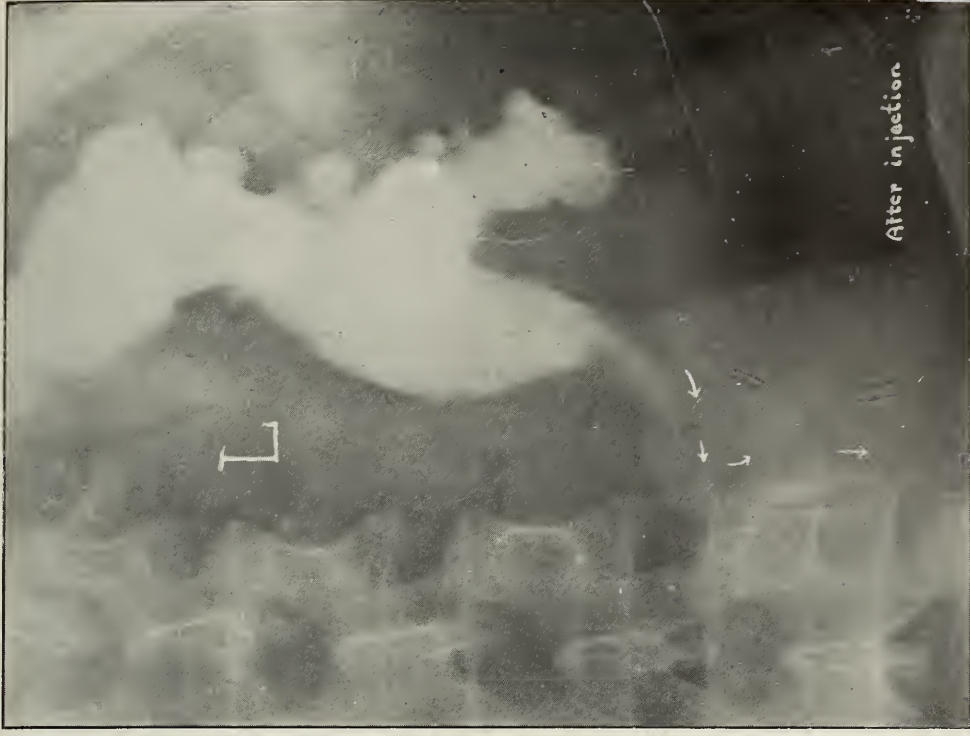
X-ray No. 13167, b. Colloidal silver shows shadow to be a large branched stone filling kidney pelvis and calyces. No hydronephrosis or pyonephrosis is associated with it. At operation multiple stones removed from cortex and large branched stone from the pelvis. No hydronephrosis or pyonephrosis was present.
